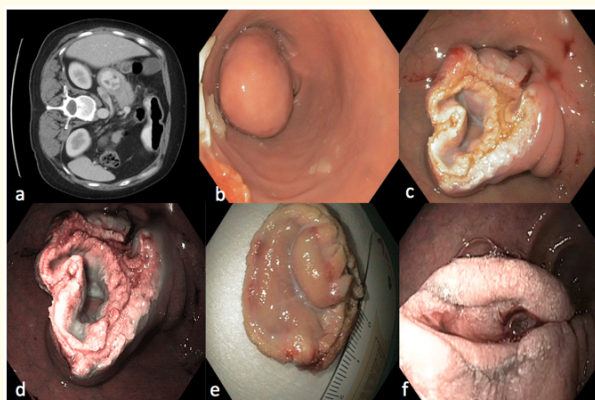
Endoscopic diverticulectomy with platelet-rich plasma of intraluminal duodenal diverticulum (IDD) (a) Abdominal CT scan with IDD. (b) Windssock diverticulum. (c) Mucosal defects with PRP cushion. (d) NBI of the resected area. (e) Retrieval tissue after EMR. (f) Follow-up endoscopy at 3 months.
